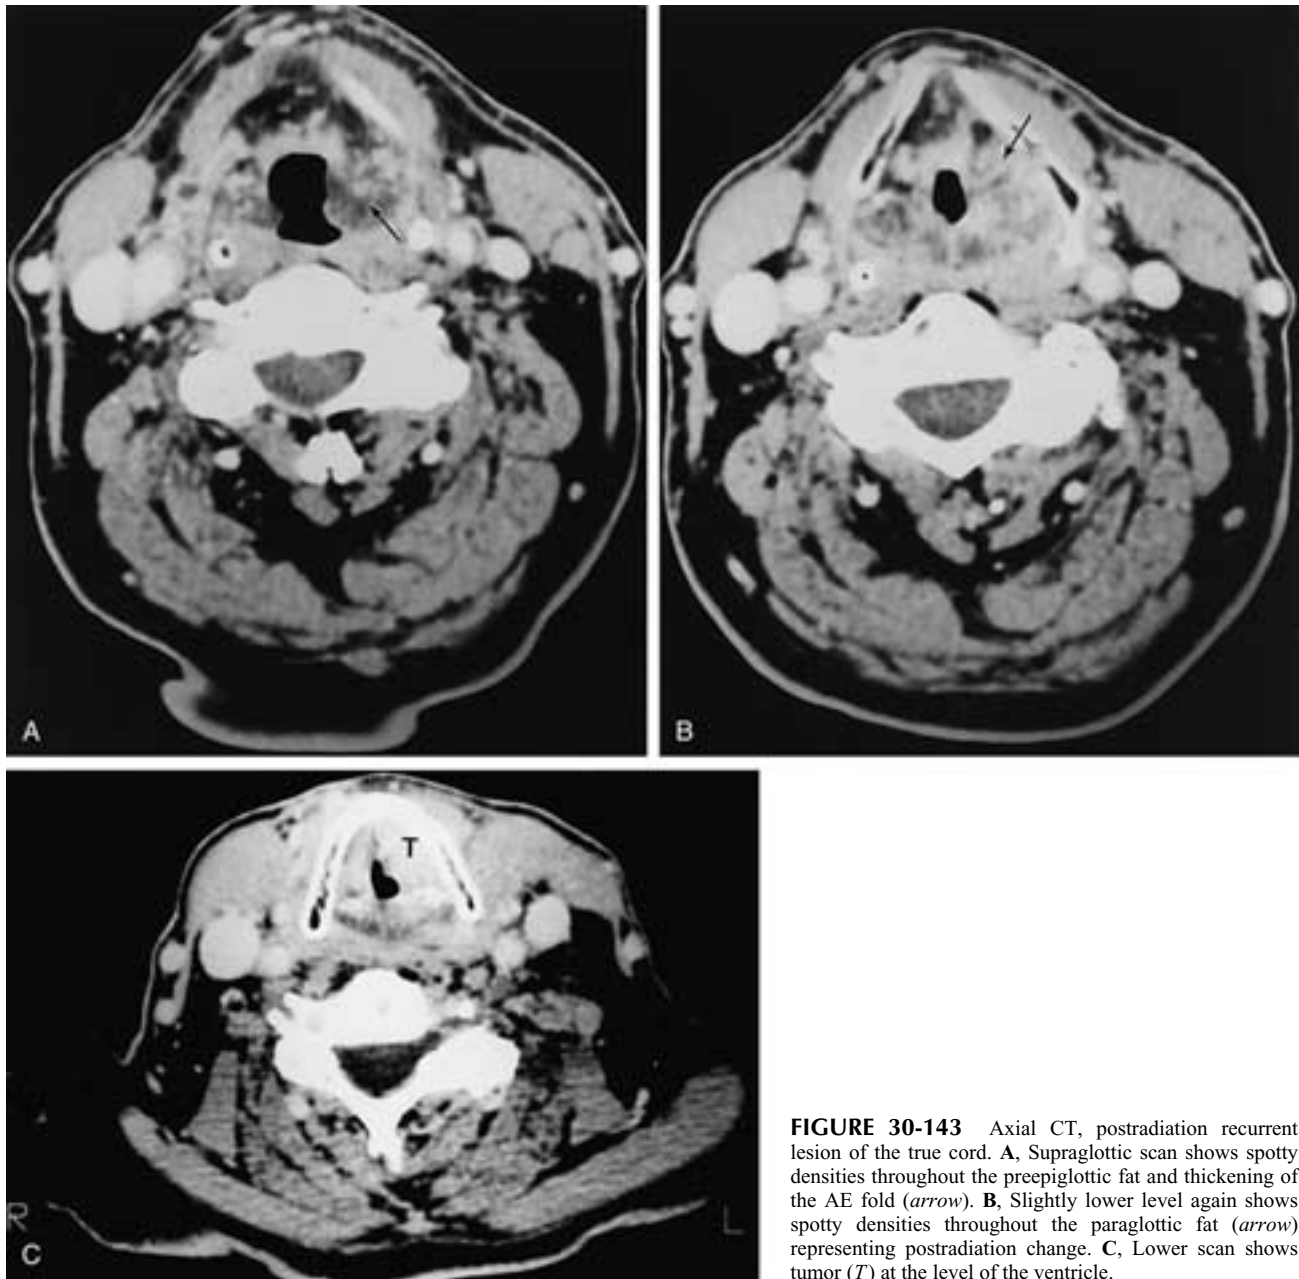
Axial CT, postradiation recurrent lesion of the true cord. A, Supraglottic scan shows spotty densities throughout the preepiglottic fat and thickening of the AE fold (*arrow*). B, Slightly lower level again shows spotty densities throughout the paraglottic fat (*arrow*) representing postradiation change. C, Lower scan shows tumor (*T*) at the level of the ventricle.
